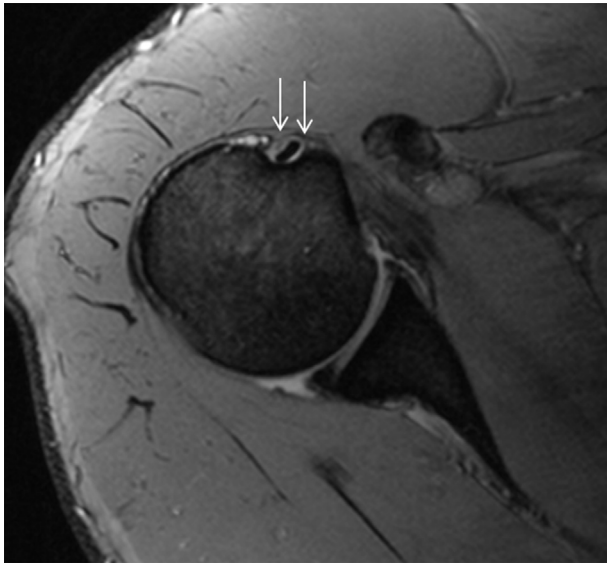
Right shoulder of a 42-year-old male with long head of the biceps (LHB) tenosynovitis demonstrated by increased signal around the LHB tendon (white arrows) on T2-weighted magnetic resonance imaging, axial view.
